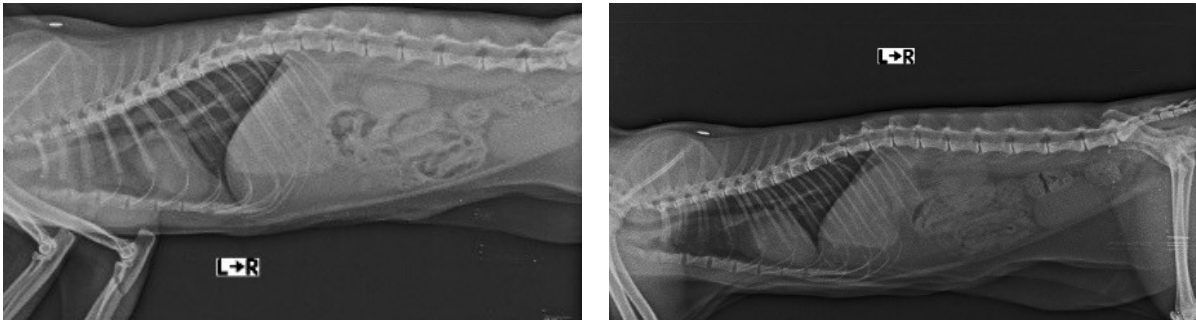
Chest radiograph on day 3 of LLLT application. A clear difference is seen in the cranial aspect of the heart.
